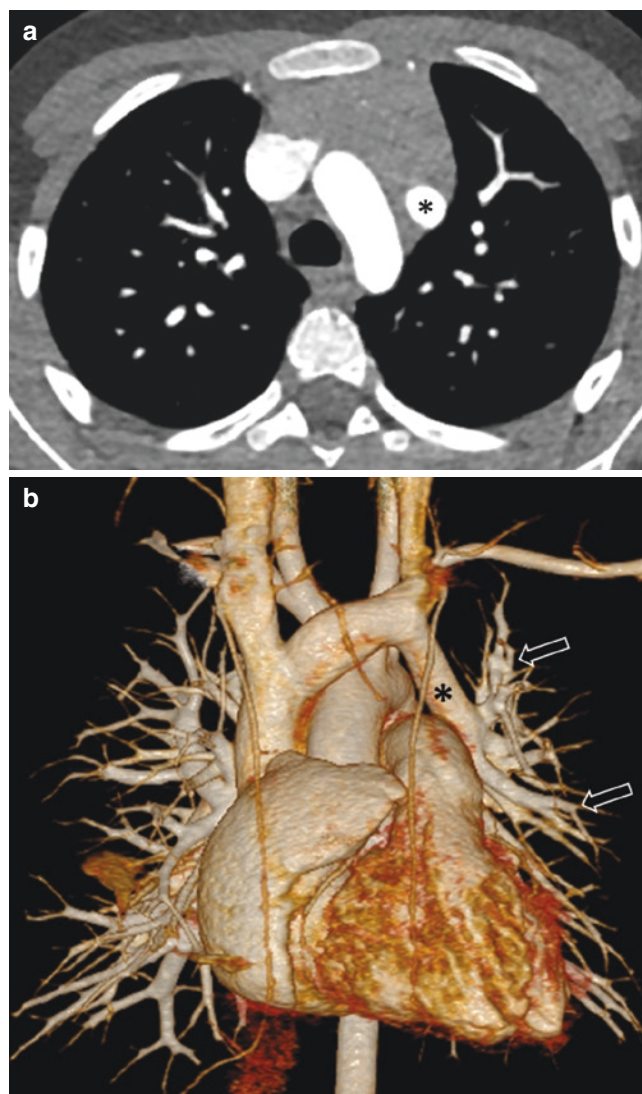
A 6-year-old girl with left upper lobe partial anomalous pulmonary venous return. Axial enhanced CT image (a) and 3D volume-rendered CT image (b) show left upper lobe pulmonary veins (arrows) draining into the vertical vein (asterisk)
